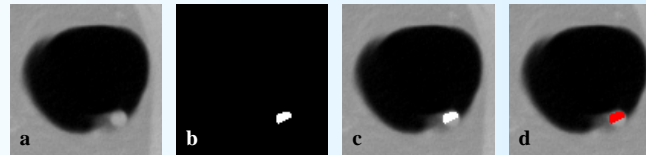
The polyp detection process: (a) Original axial CT slice (b) automatic anomaly identification (c) anomaly overlay (d) flagging (red = potential polyp)
